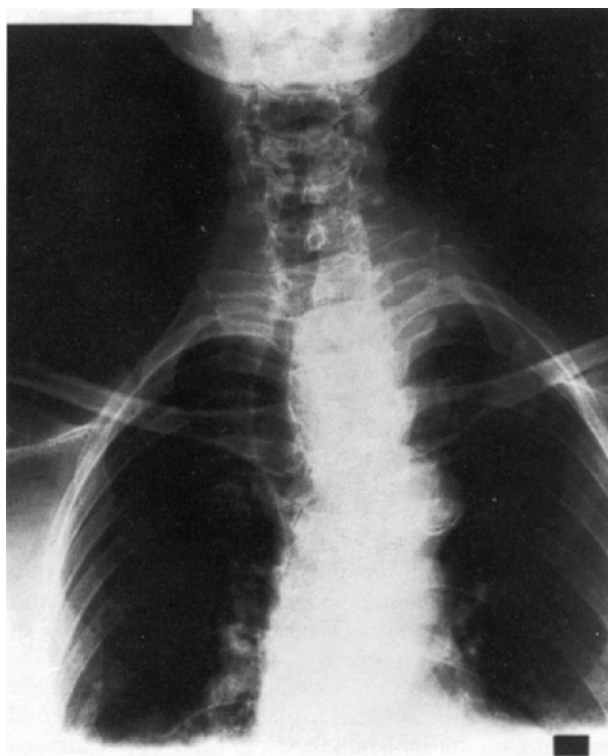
Thoracic inlet x-ray showing tracheal deviation caused by the large thyroid goitre.
